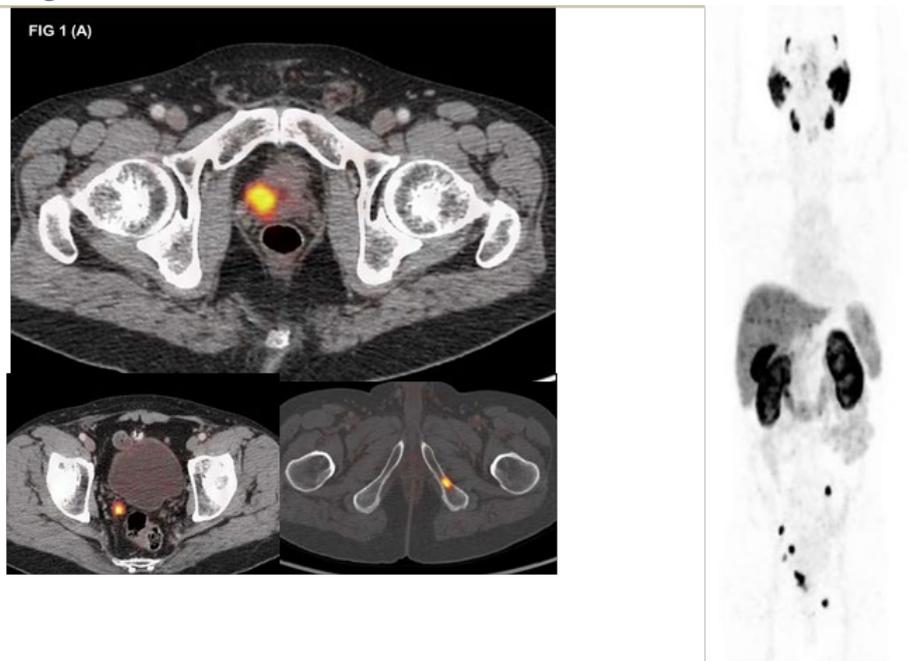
(A) axial & coronal MIP (B) image shows recurrent adenocarcinoma carcinoma prostate. Fused PET/CT images shows recurrent disease in prostate, right seminal vesicle and left ischiopubic bone metastases.
